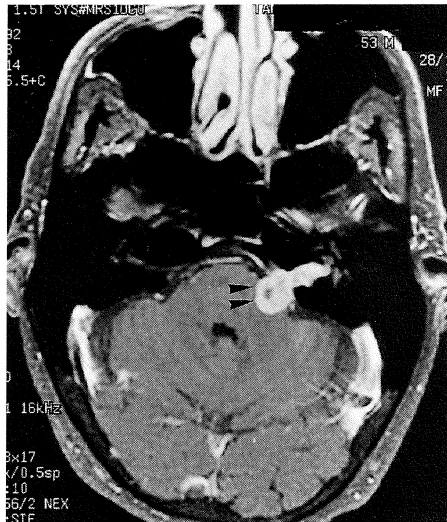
Contrast-enhanced T1-weighted spin-echo image of the same patient confirming the diagnosis of left acoustic schwannoma (arrowheads).
